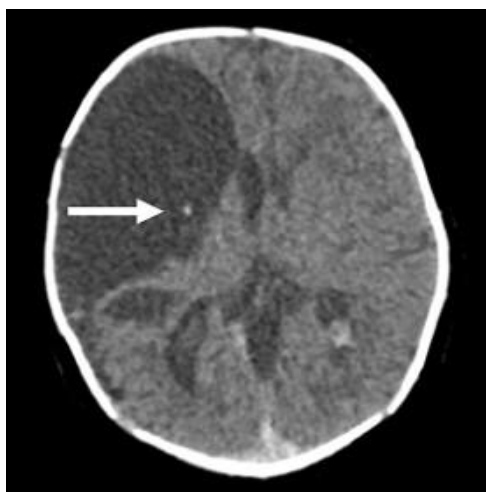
Axial CT. Intra-cystic calcification (arrow) seen within the largest porencephalic cyst, visualized using phase image analysis.
